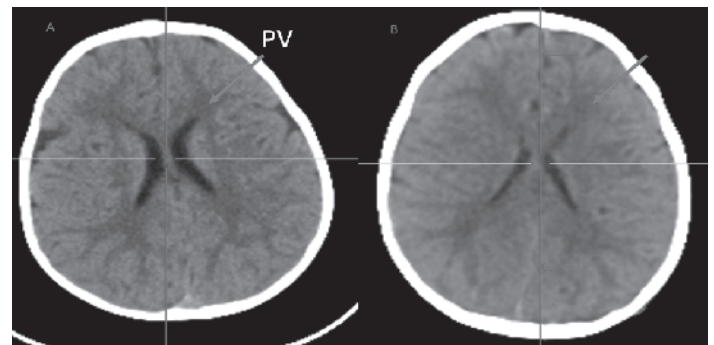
CT Brain demonstrates (A) abnormality in lateral ventricles before cellular transplantation (b) Significant improvement observed in periventricular areas after cellular transplantation
